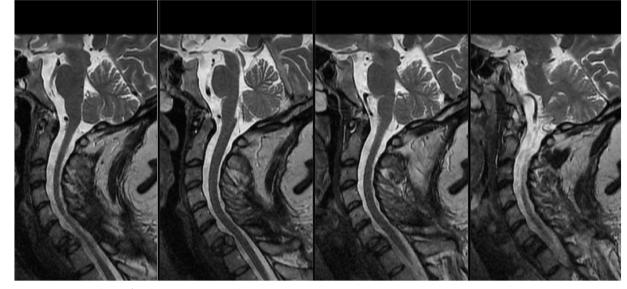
Post-operative cervical MRI after the metastatic cervical tumor resection.
